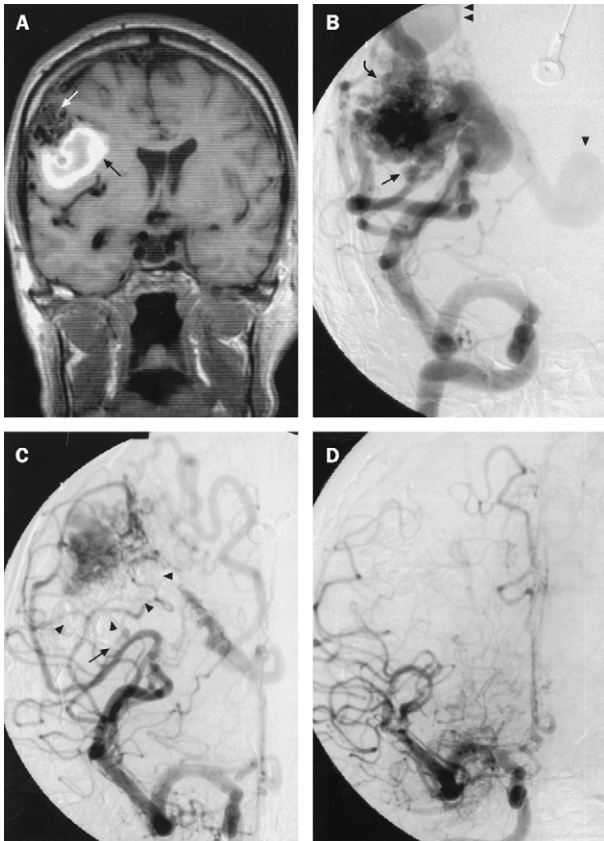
MRI scan (A) and diagnostic angiograms (B-D) of a 42-year old right-handed man with an arteriovenous malformation (AVM)
